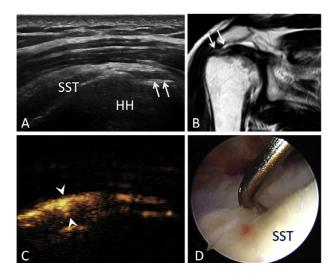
Intact rotator cuff in a 33-y-old male diabetic. (A) Ultrasound revealed a focal hypo-echoic tendon, but could not differentiate the bursal-side partial-thickness tear from the full-thickness tear (\\$\\$\\$\\$\\$) in the long-axis view. (B) An oblique coronal T2-weighted image revealed a brighter signal on the bursal side of the involved tendon (\\$\\$\\$\\$\\$\\$) that appeared to be consistent with poor elasticity. (C) Percutaneous ultrasound-guided subacromial bursography image revealed contrast agent filling and outlining the tear area of the bursal-side tendon (arrowhead). Thus, the lesion was misdiagnosed as a bursal-side partial-thickness tear in the long-axis view. (D) Arthroscopy confirmed a stiffer, less elastic tendon with no tear. HH = humeral head; SST = supraspinatus tendon.
